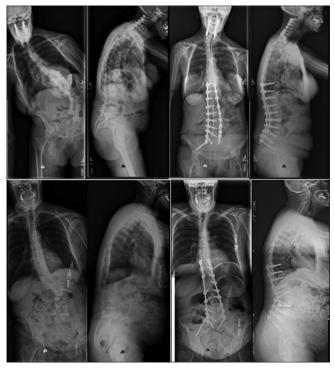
Preoperative and two-year postoperative posteroanterior and lateral radiographs of spinopelvic fixation in (upper row) a patient who underwent direct lateral interbody fusion (DLIF) L2-L5 and SPF with a unilateral S2 sacro-iliac screw and (lower row) a patient who underwent SPF with a unilateral iliac bolt
